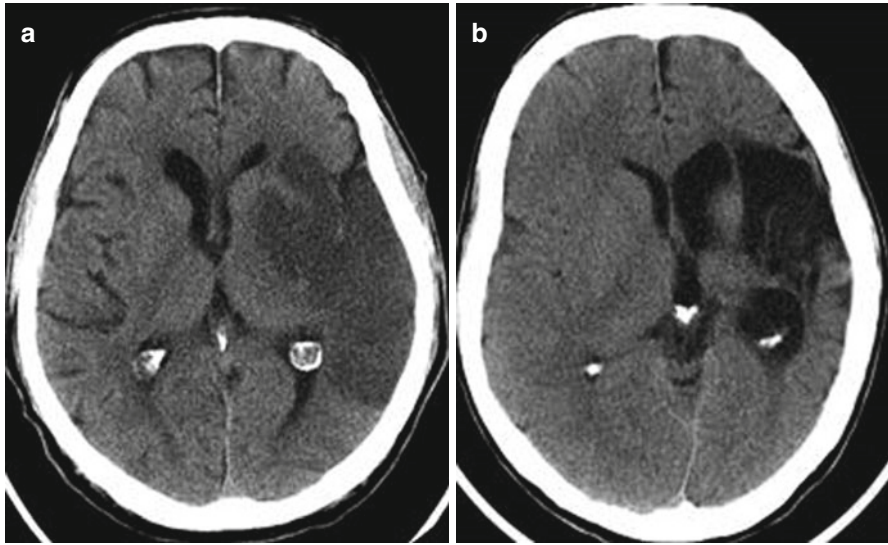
Evolution of the lesion in ischaemic stroke in the territory of the left MCA. CT scan shows hypodense lesion in the left temporal lobe indicating the subacute stage of infarction (a). CT image at 3 months (b) shows the reduction in the size of the lesion, cavity formation, local brain atrophy and ex vacuo dilatation of the left lateral ventricle
